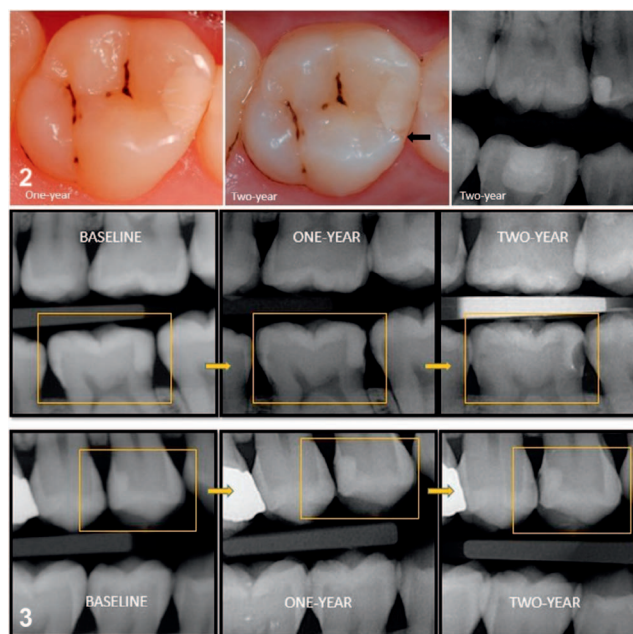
One-year and two-year clinical appearance and two-year radiography of an Equia Forte Fil (EF) restoration. At the two-year evaluation, marginal fracture was observed.
